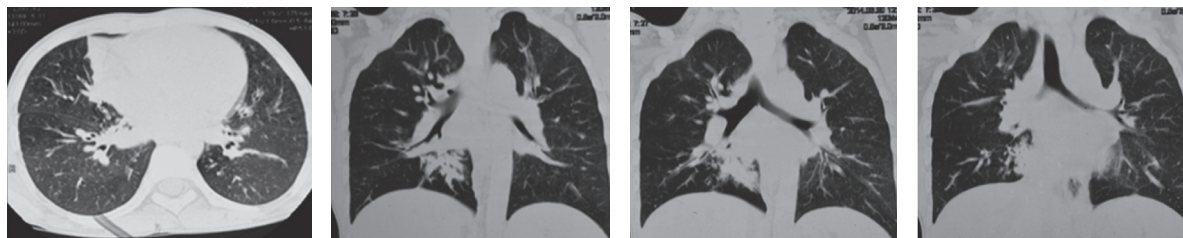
A 13-year-old male patient. A. HRCT image shows a wedge shaped parenchymal lesion in medial segment of right middle lobe seen suggestive of consolidation.
